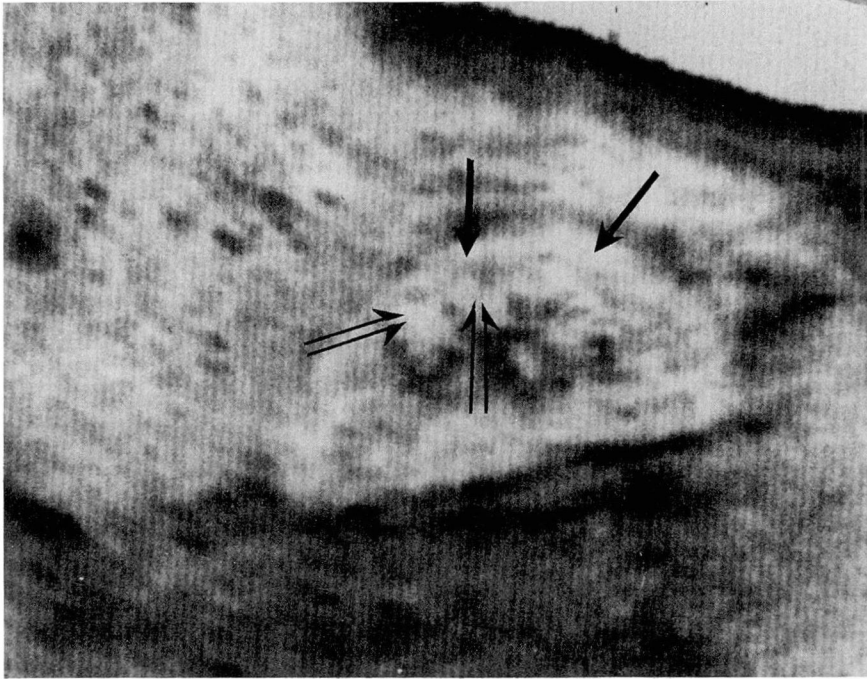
Ultrasonogram of normal kidney. Note the compartmental anatomy identified by ultrasonography (renal cortex) (single arrows), the clearer medullary pyramids (double arrows), and the dense echoes of the renal hilum. The renal pelvis is collapsed, hence, it is not visualized.
